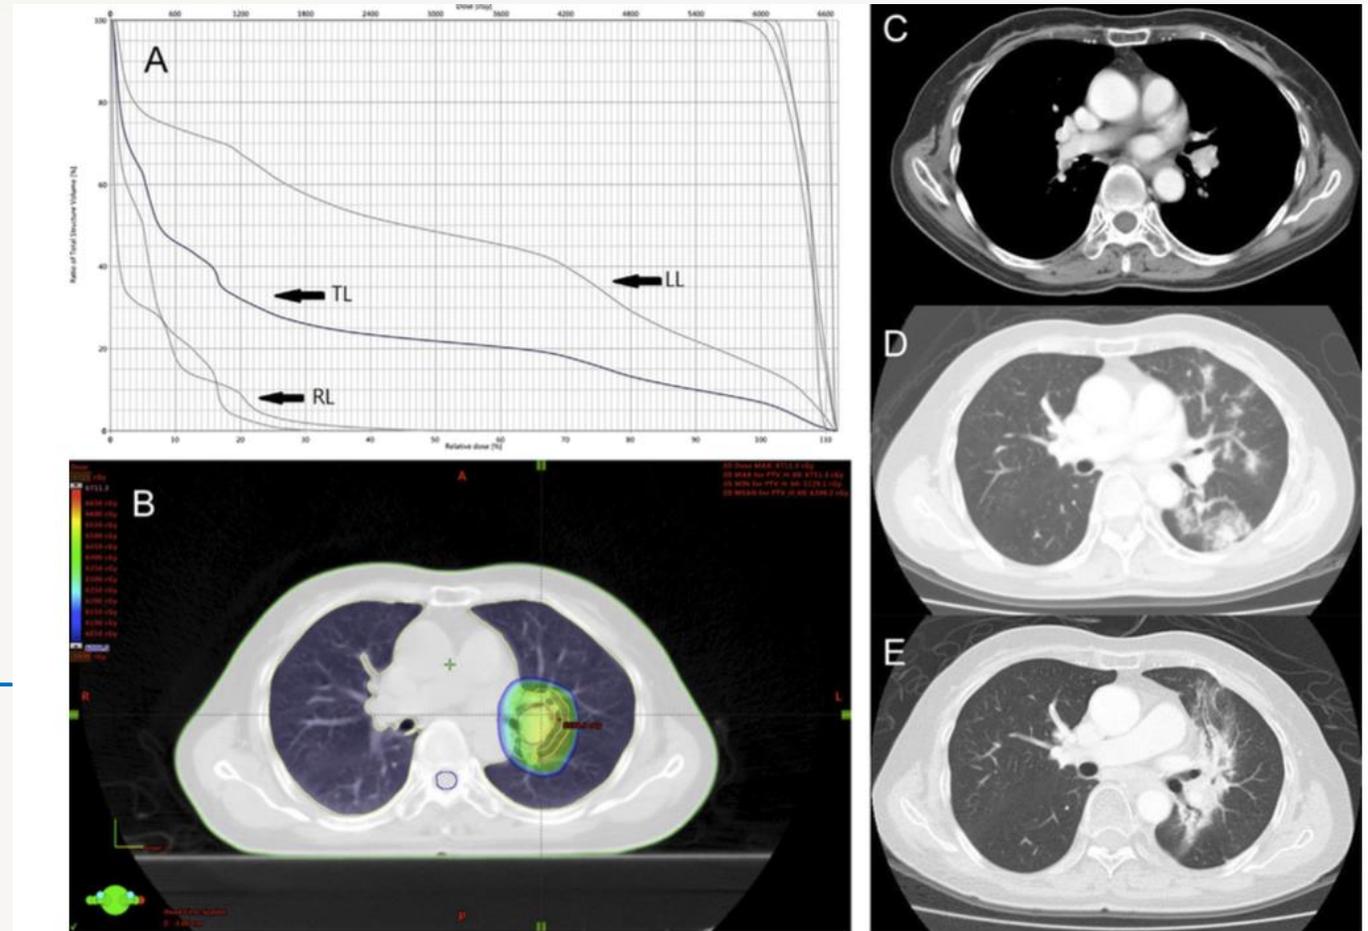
A representative case with epidermal growth factor receptor-tyrosine kinase inhibitor-related radiation recall pneumonitis (Case 3): (A) the dose-volume histogram of thoracic radiotherapy; (B) computed tomography (CT)-based three dimensional-conformal radiotherapy plan; (C) CT scan of chest obtained before radiotherapy; (D) CT scan after the end of radiotherapy; and (E) radiation pneumonitis induced by erlotinib, which developed 126 days after the end of radiotherapy. LL = left lung; RL = right lung; TL = total lung.
